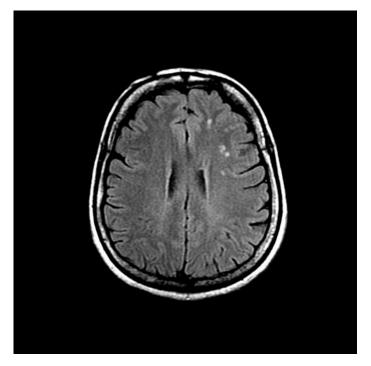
A 44-year-old female patient with tension-type headache has multiple white matter hyperintensities on FLAIR image
